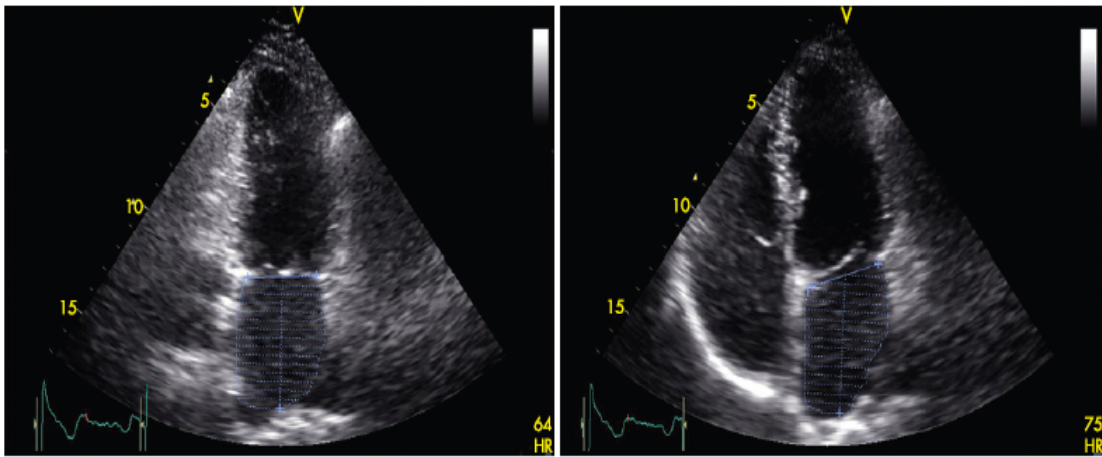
Measurement of Left Atrial volumes with transthoracic echocardiography using the modified biplane Simpson's rule. The maximum Left Atrial volume is assessed during ventricular systole in the apical two-chamber (left panel) and apical four-chamber (right panel) views. Maximal Left Atrial volume was 46 ml; minimal Left Atrial volume was 22 ml, resulting in a Left Atrial ejection fraction of 53%.
